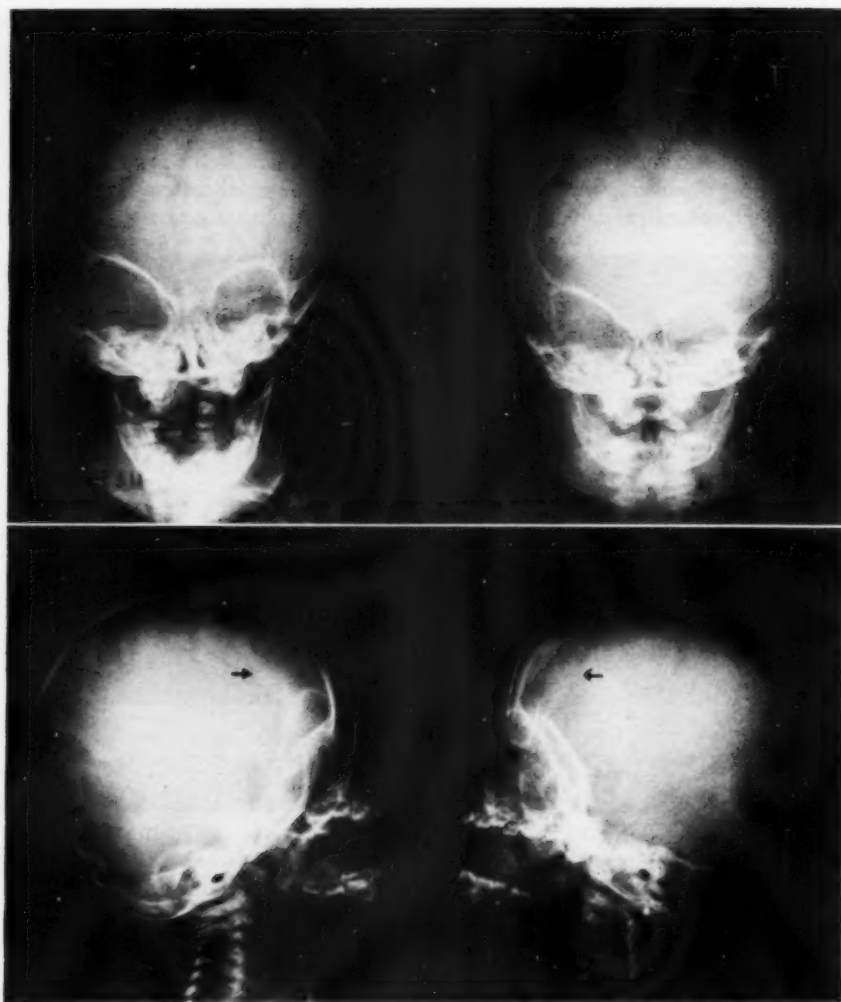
Nine-month-old female who had an asymmetrical skull with the right frontotemporal region flattened as compared with the left side. Above are two postero-anterior roentgenograms of different densities. The right half of the coronal suture is closed (arrows). All the other sutures are open. Note also the upward and lateralward slant of the roof and lateral border of the right orbit. The metopic suture curves over to the right. Below are two lateral views which show the right half of the coronal suture to be closed (arrows). This is a case of plagiocephaly.
